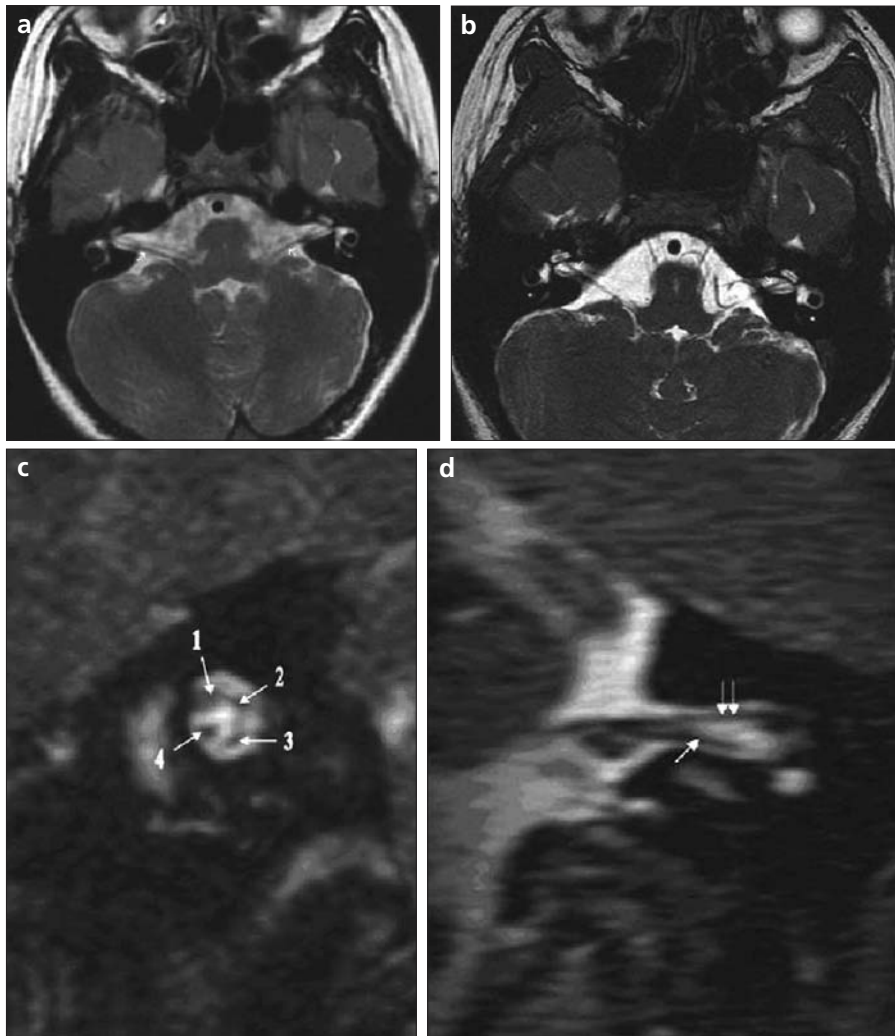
a–d. Cranial nerves VII and VIII. On axial FSE T2W MR image (a), nerves VII and VIII can be roughly visualized (arrows). On axial 3D FIESTA MR image (b) and coronal (c, arrow 1: facial nerve; arrow 2: superior vestibular nerve; arrow 3: inferior vestibular nerve; arrow 4: cochlear nerve), and sagittal (d, double arrows: VII. nerve; single arrow: VIII. nerve) MIP reconstructions of 3D FIESTA sequences, all segments of the nerve complex are visible.
